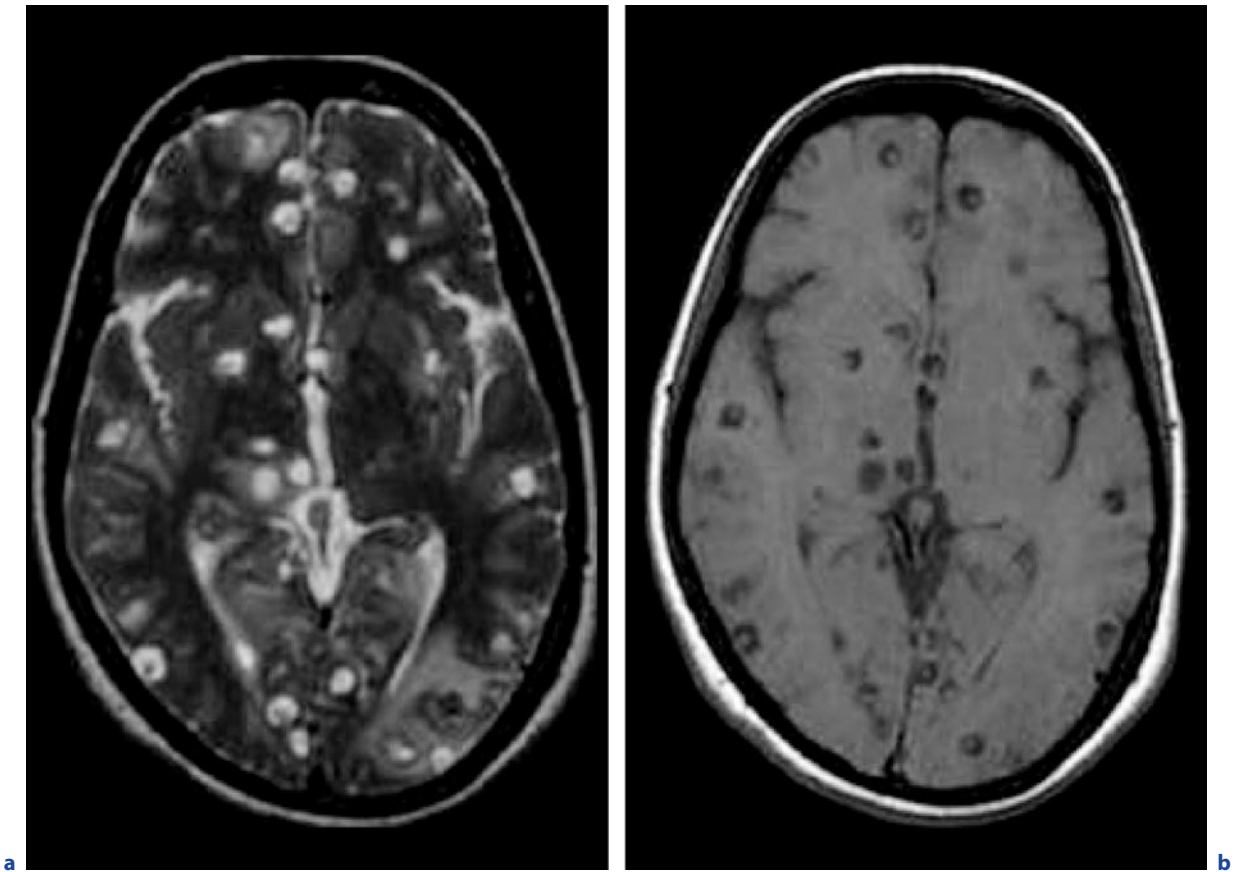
Multiple neurocysticercosis cysts in a 25-year-old man with headache, nausea, and vomiting. a Axial T2-weighted image. b Axial T1-weighted image before contrast administration. c–e see next page
